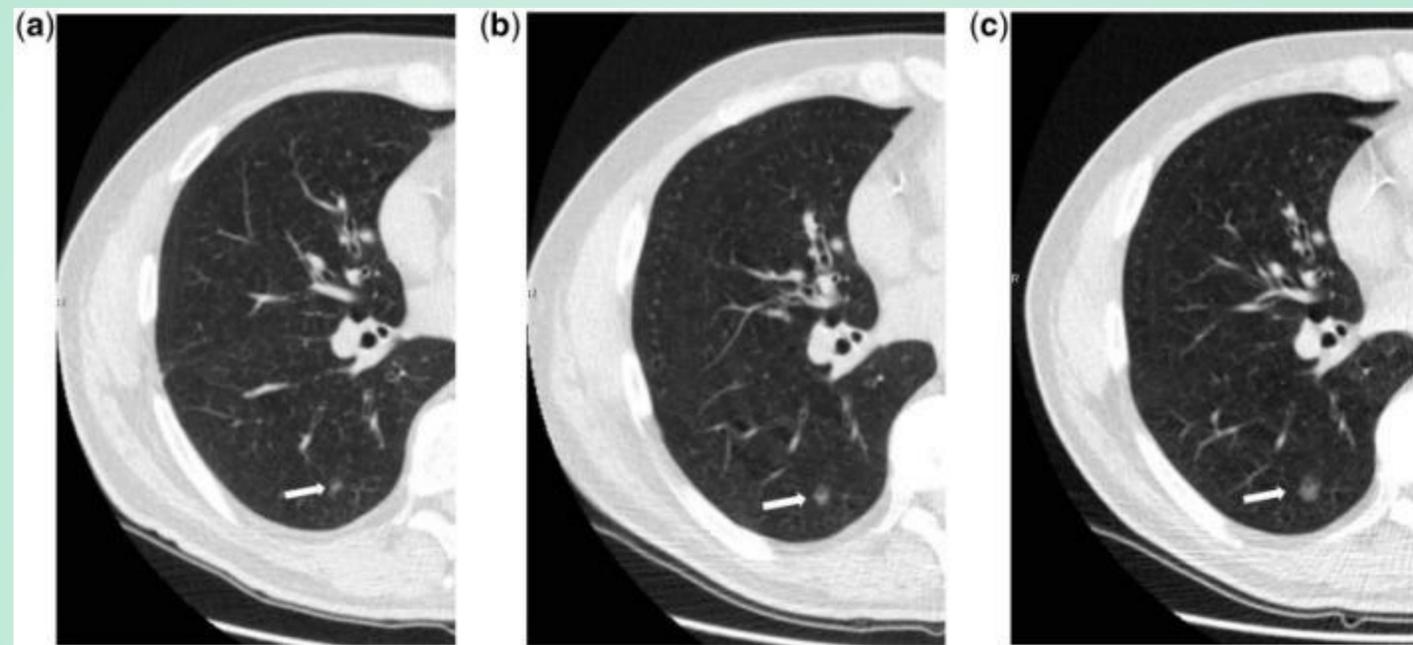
Transverse unenhanced low-dose CT scans show a slow-growing pulmonary nodule of the lower right lobe in a 61-year-old man. In 2012, the nodule was surgically removed and was found to be adenocarcinoma of the lung. The nodule measured 5.5 mm in 2007 (a), 8.5 mm in 2009 (b) and 11 mm in 2012 (c).⁵
